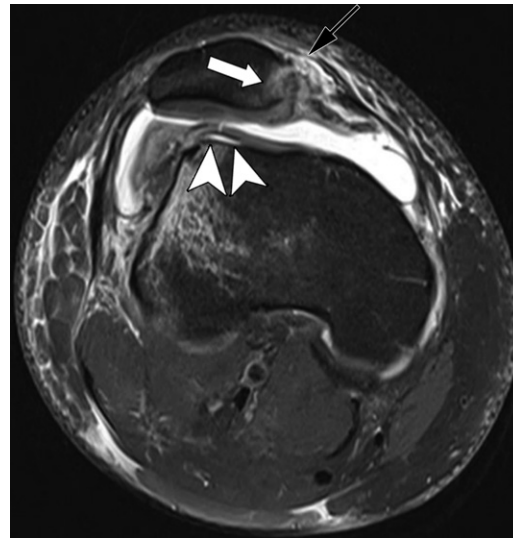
Transient patellar dislocation with osteochondral injuries in a 22-year-old man. Axial PD-weighted fat-suppressed MR image after acute lateral patellar dislocation shows osteochondral injuries involving the medial patella (white arrow) and lateral trochlea (arrowheads). There is also tearing of the patellar attachment of the MPFL (black arrow). Note the shallow upper trochlear groove and lateral femoral condylar edema.
